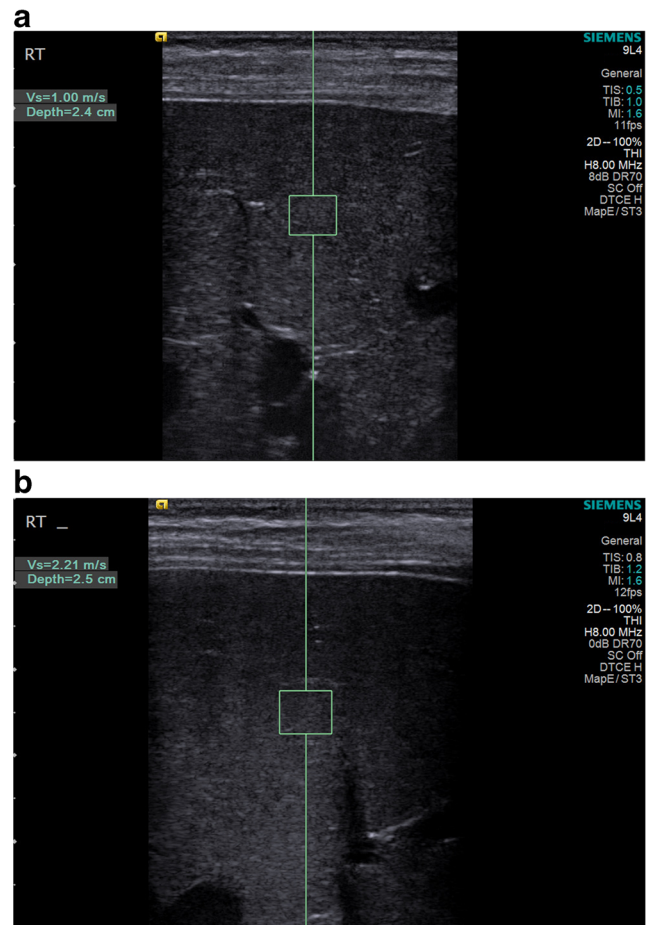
Ultrasound hepatic point shear wave elastography images from a 34-month-old female patient with single ventricle congenital heart disease. a Point shear wave elastography (p-SWE) image obtained prior to stage 3 of the Fontan operation shows normal liver stiffness (shear wave speed measurement = 1.00 m/s). b p-SWE image obtained 24 h after surgery shows marked interval liver stiffening due to hepatic congestion (shear wave speed measurement = 2.21 m/s)
